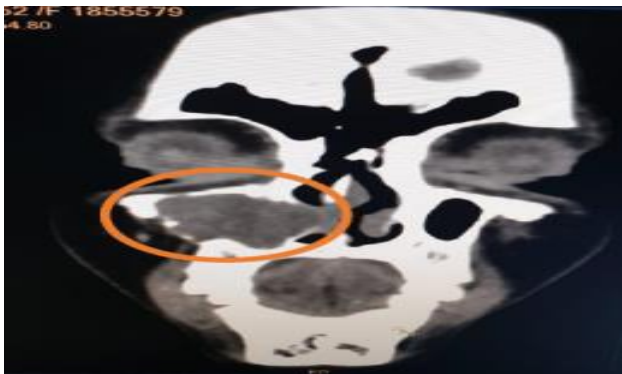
Mass seen in coronal section of CT PNS.
